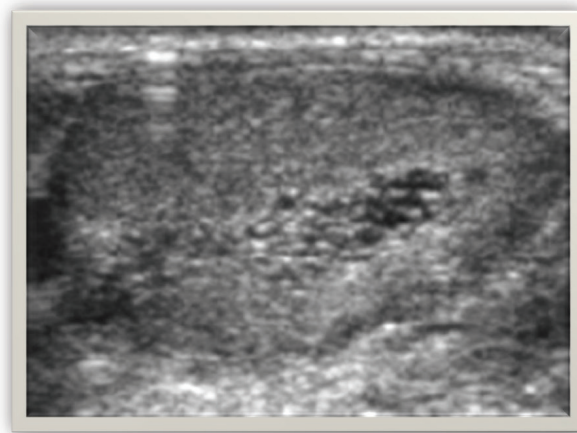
Ultrasound image of Cystic transformation of rete testes
